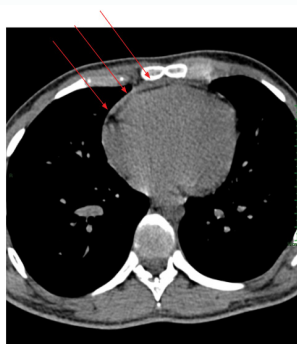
Chest CT showing small pericardial effusion.
